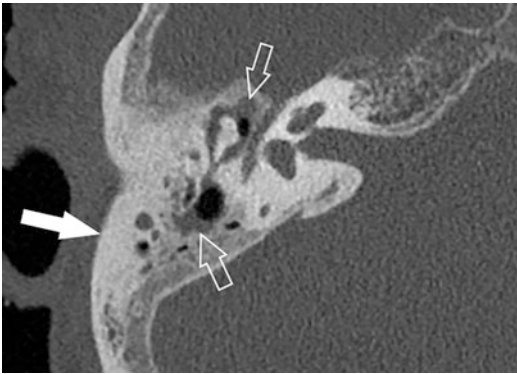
Chronic otomastoiditis. Axial CT image shows opacification in the middle ear cavity, mastoid antrum and mastoid air cells (open arrows). Poor pneumatization of mastoid air cells with sclerotic changes is noted (solid arrow)
